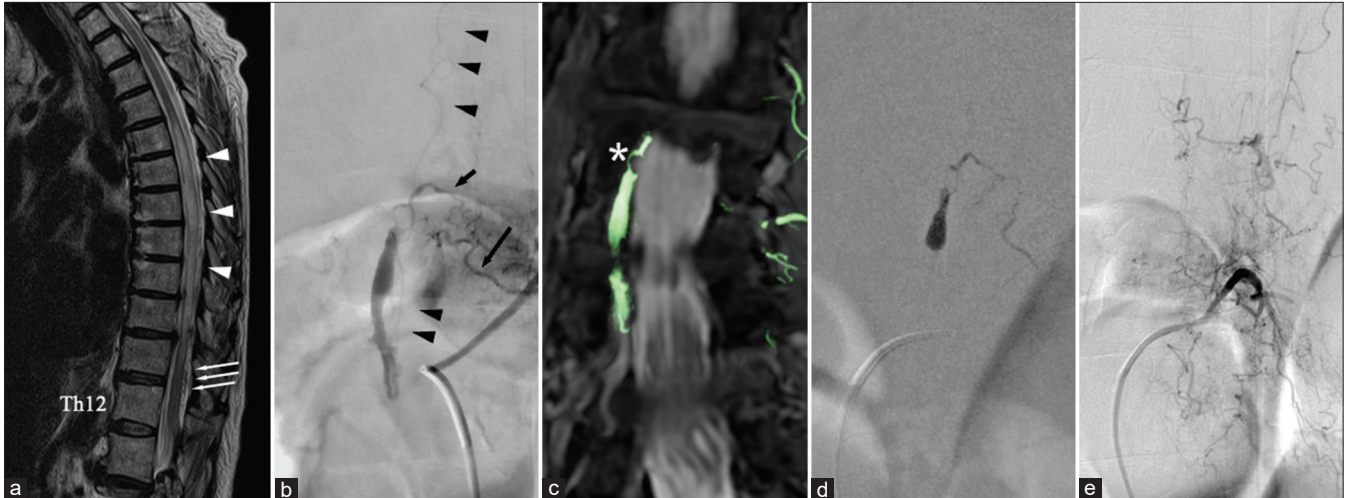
(a) Sagittal view of T2-weighted magnetic resonance imaging (MRI) of the spinal cord shows a diffuse high signal intensity from Th5 to Th11 (arrowheads) and multiple flow voids in the subarachnoid space (arrows). (b) Preoperative spinal angiography from the left L2 segmental artery reveals a spinal epidural fistula supplied from the dorsal somatic branch (long arrow) through retrocorporeal anastomosis (short arrow). The shunt forms a venous pouch and cranially drains through the posterior spinal vein (arrowheads). (c) The fusion image of MRI and maximum intensity projection shows the shunt point located in the lateral epidural space (asterisk). (d) NBCA injected from the microcatheter infiltrates into the shunt points and upper part of the venous pouch. (e) Postoperative angiography shows complete obliteration of the shunts with remnant venous congestion.
